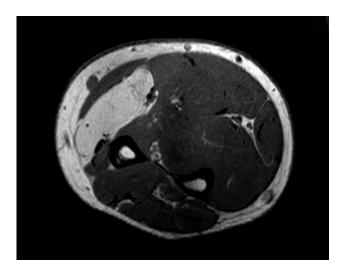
Transverse MRI view of the right forearm again showing the hyper intense mass.
